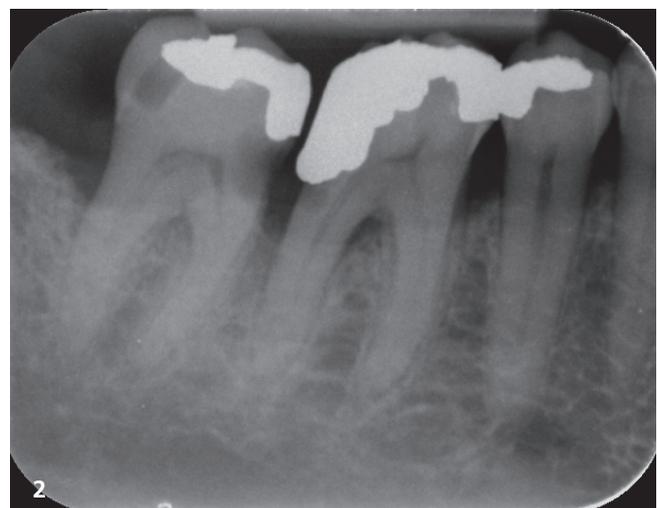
Initial situation, intra-oral view. – Fig. 2: Pre-op radiograph.
